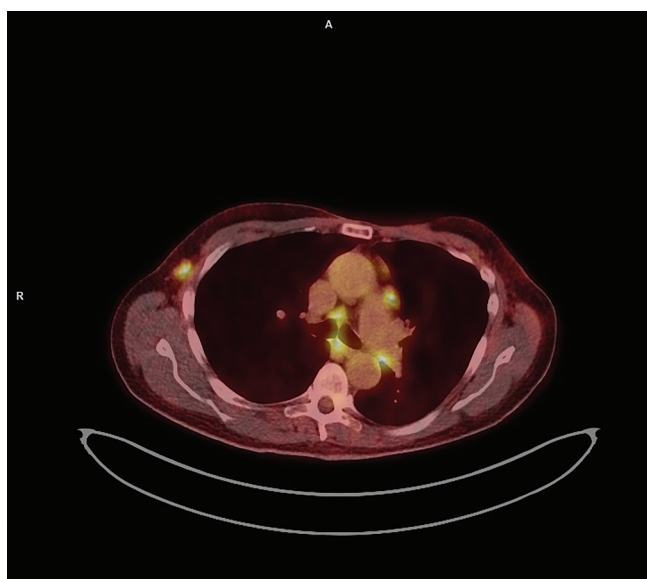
^{18}F -FDG PET/CT fusion image of lymph node metastasis
